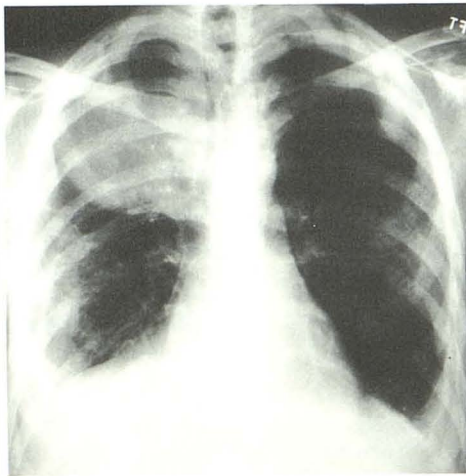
Posteroanterior chest radiograph shows sclerotic bone metastases, bilateral pleural effusions, and multiple pleural mass lesions.
